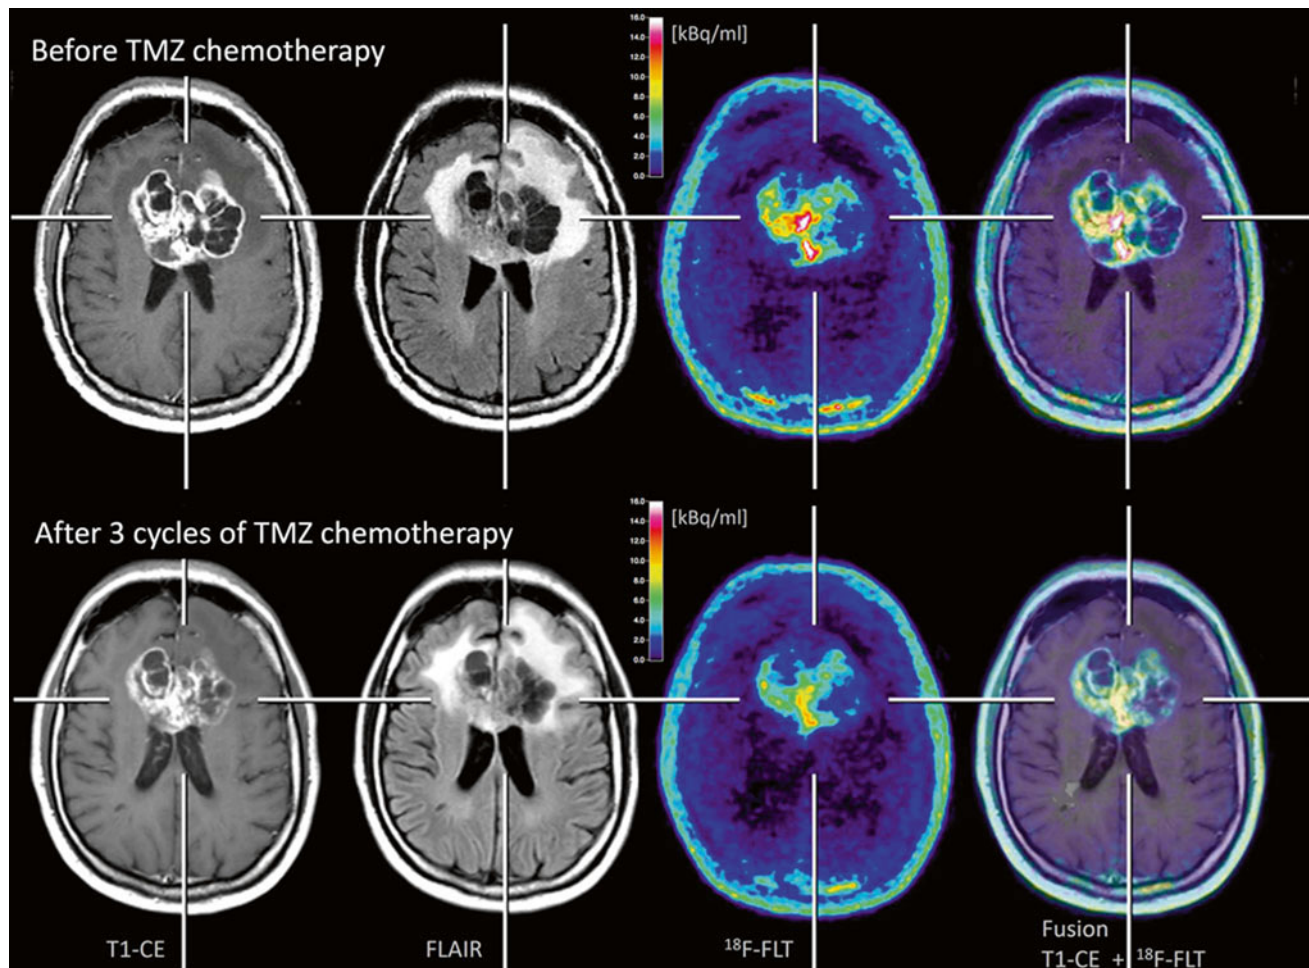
Patient with a glioblastoma before (*upper row*) and after three cycles of temozolomide (TMZ) chemotherapy (*lower row*). A moderate reduction of tumor extent is observed both in the contrast-enhanced MR and FLAIR-weighted images as well as in the ^{18}F -FLT PET scans.
